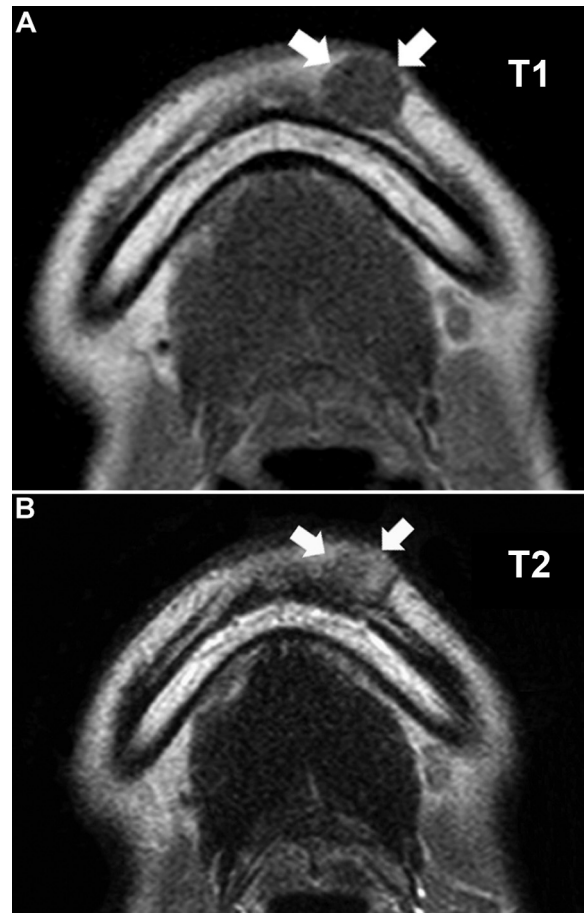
Magnetic resonance imaging of initial visit. A magnetic resonance imaging examination showed a well-demarcated homogenous lesion of the left chin with a low signal intensity on T1-weighted images and a moderate signal intensity on T2-weighted images (arrow).
